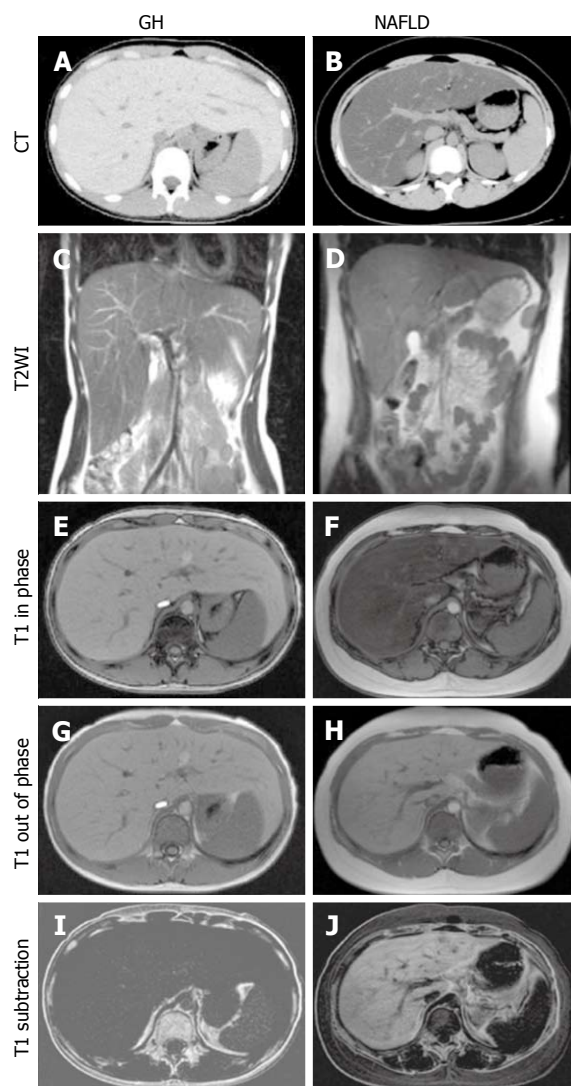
Computed tomography (CT) and magnetic resonance imaging (MRI) of (A, C, E, G, I) glycogenic hepatopathy (GH) in a 13-year-old girl and (B, D, F, H, J) non-alcoholic fatty liver disease (NAFLD) in a 13-year-old boy. On CT, GH was (A) high density, but NAFLD was typically (B) low density; On T2-weighted imaging (T2WI), both enlarged livers were (C) 19.1 cm and (D) 16.8 cm along the right midclavicular line; On gradient dual-echo MRI, the GH liver was iso-intense between the (E) in-phase and (G) out-of-phase images, namely; I: Low intensity on subtraction. The NAFLD liver, however, had low intensity on the (F) in-phase image, and high intensity on the (H) out-of-phase image, namely; J: High intensity on subtraction. With permission from Saikusa *et al*^[22], John Wiley and Sons publications.
